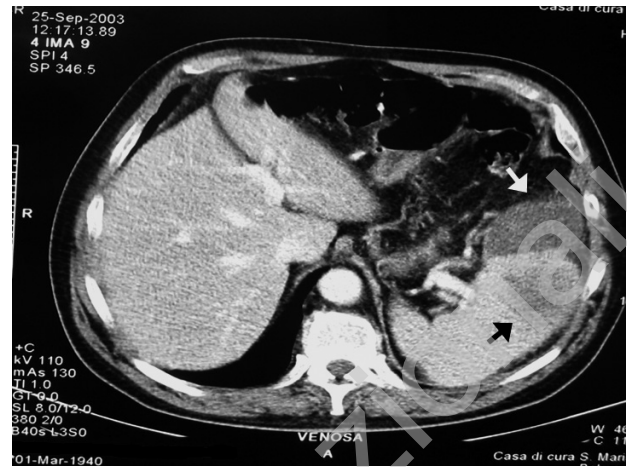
Enhanced abdominal CT scan. Previous subcapsular hematoma organization (white arrow), and intraparenchymal rupture with hemorrhage (black arrow).
